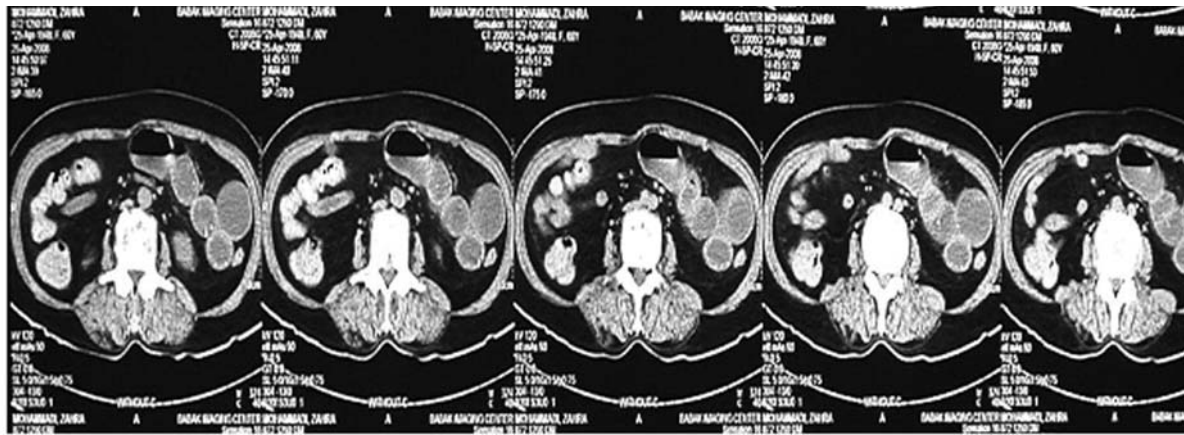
an abdominal CT Scan showing intestinal obstruction.
